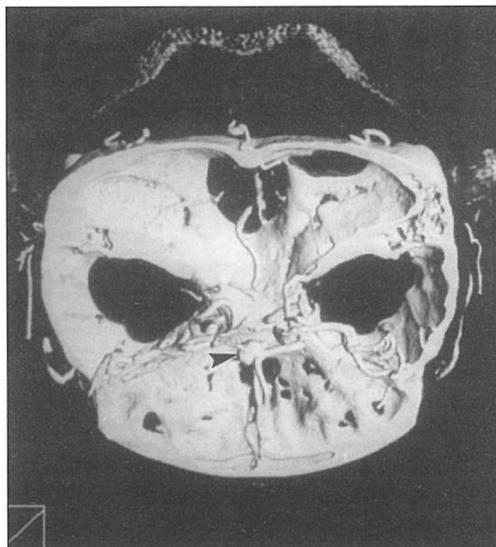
Three-dimensional computed tomographic angiographic image, posterior view, demonstrates a 9-mm-diameter anterior communicating artery aneurysm (arrow).
